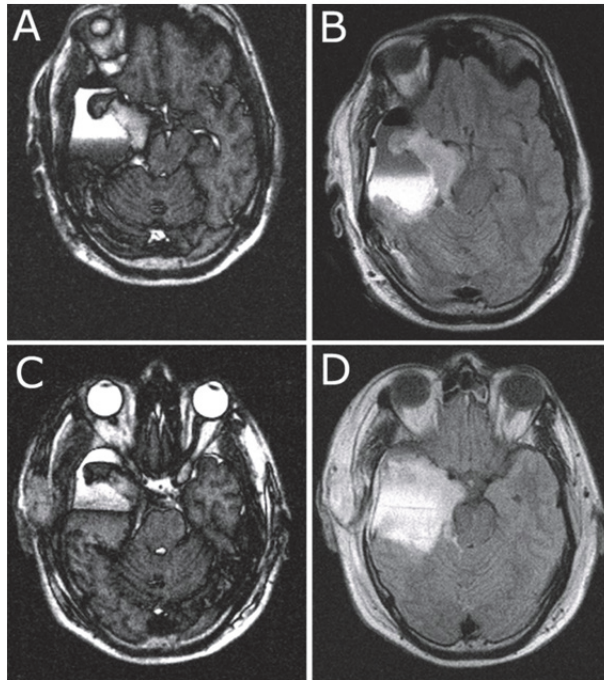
(Case 1). A large cystic tumor is in the right temporal lobe (low-grade fibrillary astrocytoma, WHO grade II).  $T_2$  (A) and  $T_1$  (B) sequences show the tumor, but the delineation of the tumor is not clear. The inner structure of the tumor seems homogenous in both (A) and (B). FLAIR (C) shows the inner structure of the tumor better, but the IR sequence with TI of 600 ms (D) and TI of 800 ms (E) are the sequences that in addition make the margins of the tumor most visible.
